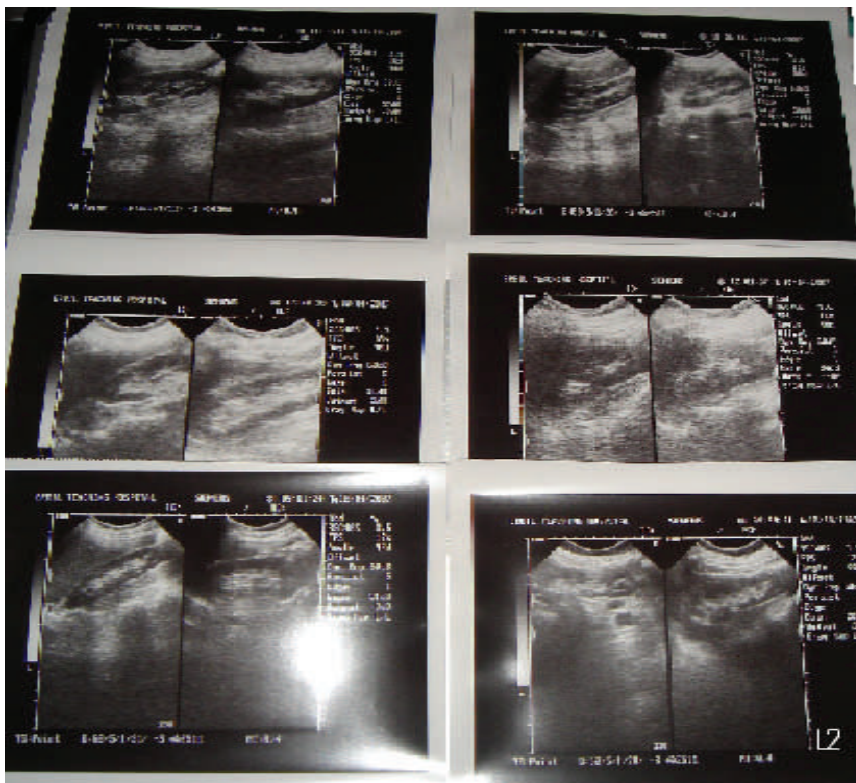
Sonographic figures of renal pelvises in positive PCSD
